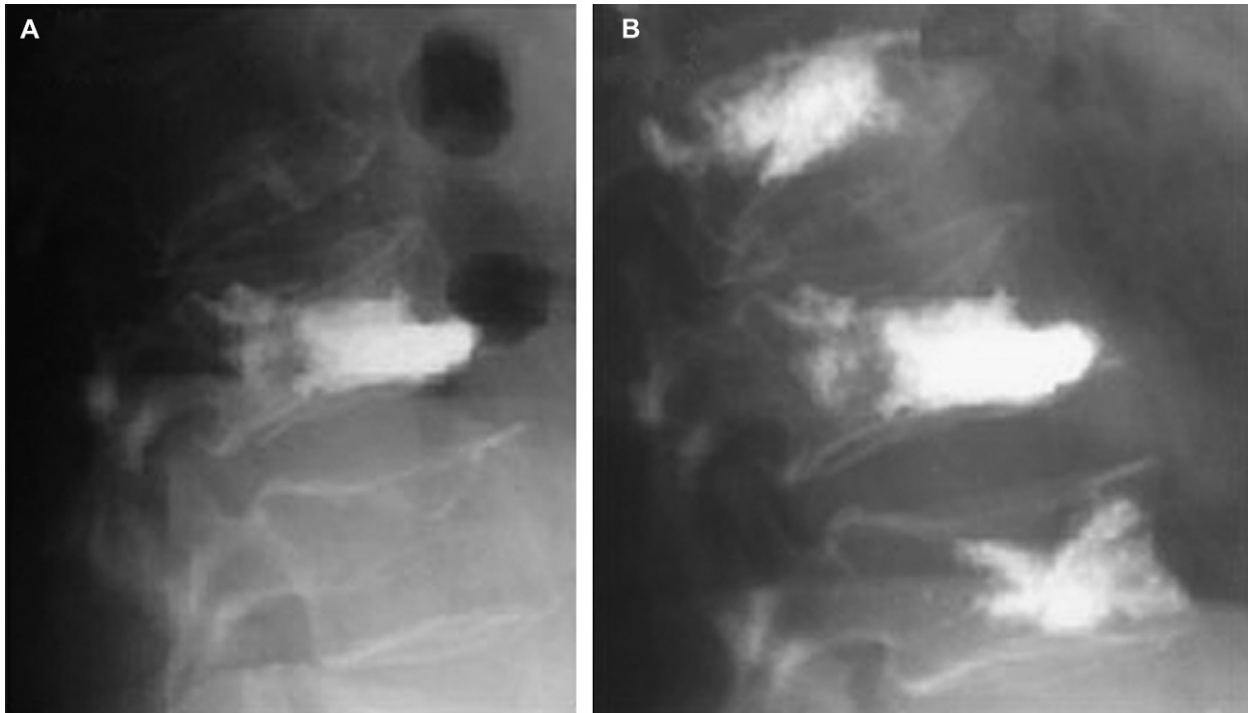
X-ray films showing an L3 compression fracture treated via (A) kyphoplasty. The patient developed severe recurrent back pain at 3 months post-operatively. Adjacent-level fractures were noted at L2 and L4 and subsequently treated via (B) vertebroplasty.
